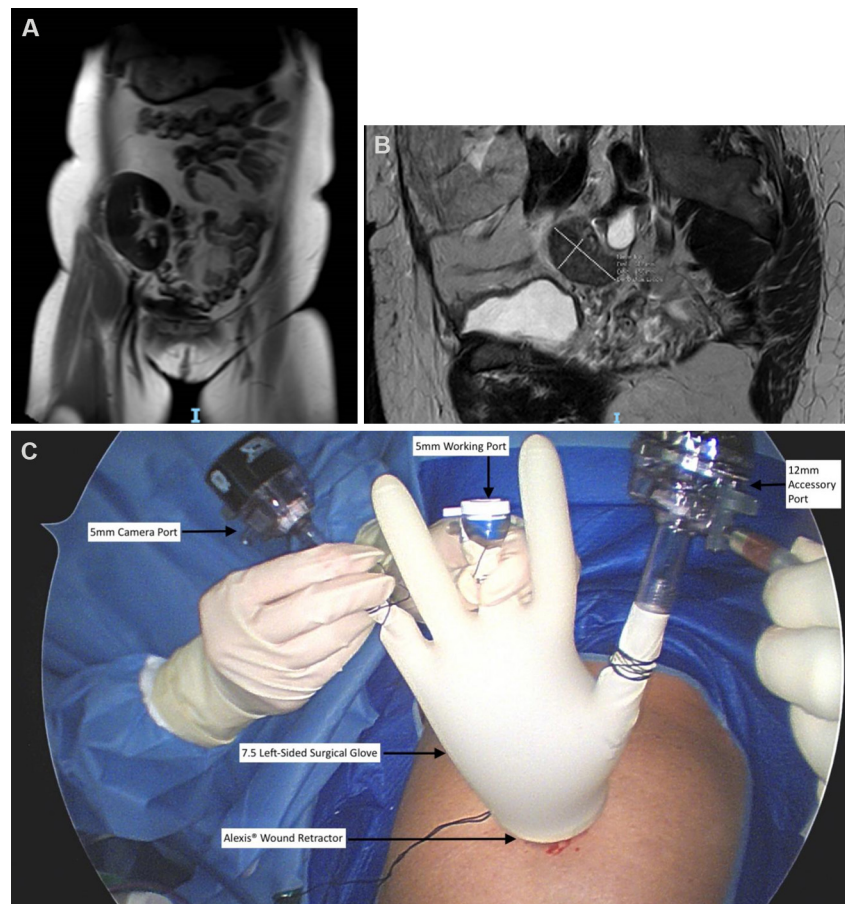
Pelvic MRI showing the transplanted kidney in the right iliac fossa (A). Pelvic MRI showing the right adnexal mass, measuring 25 mm × 17 mm × 23 mm (B). Labelled photo of the homemade single-port system (C).
